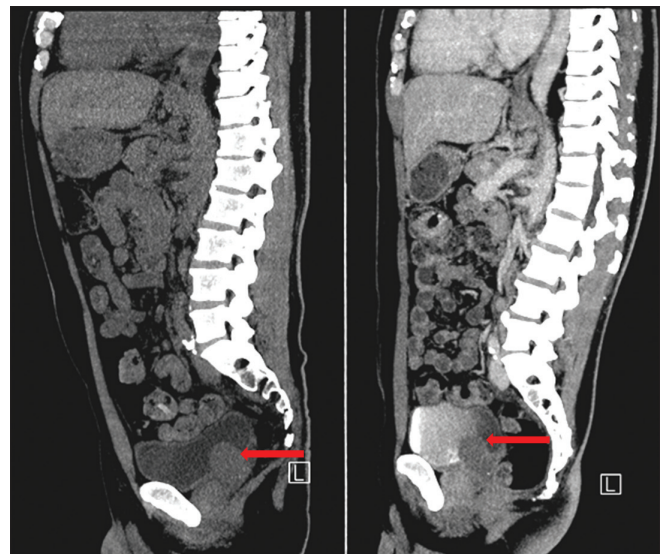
A sagittal view of the CT urogram with and without contrast, showing the seminal vesicle cyst
